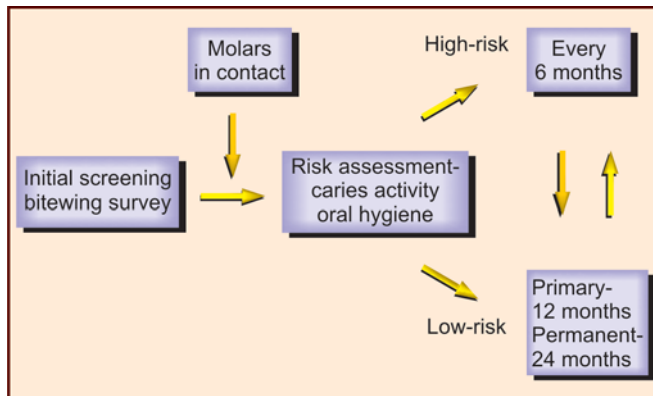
Radiographic indications
